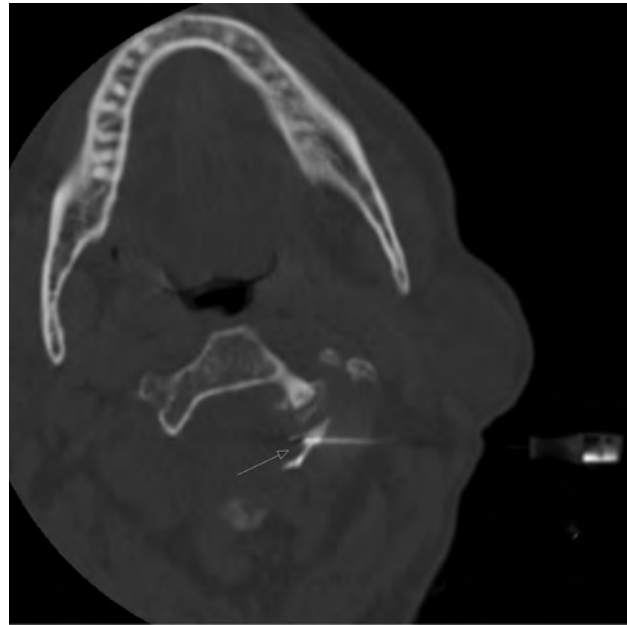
Intraprocedural axial CT image (patient 8) showing contrast injection surrounding the left the C2 DRG (arrow).
